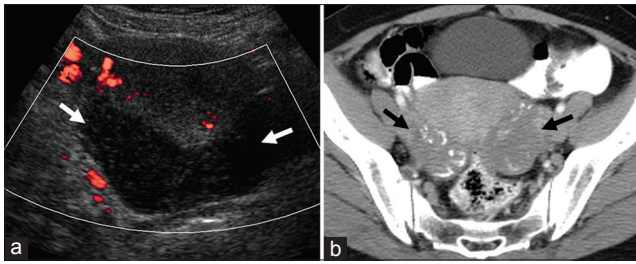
26-year-old woman with chronic tubercular salpingo-oophoritis. (a) Transverse ultrasound image of the pelvis reveals hypoechoic masses (arrow) in both the adnexae. (b) Axial CECT image through the pelvis demonstrates bilateral tubo-ovarian masses with calcification (arrows).
